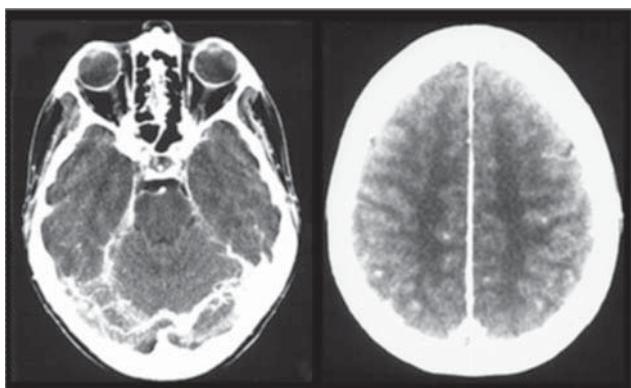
Enhanced CT scan (intense contrast enhancement of the tentorium associated with dilated transcerebral veins indicating a major venous stasis, in relation to an extensive S.S.S. thrombosis; empty delta sign). Women, 37 years old, puerperium with headache, papilledema and seizures.
